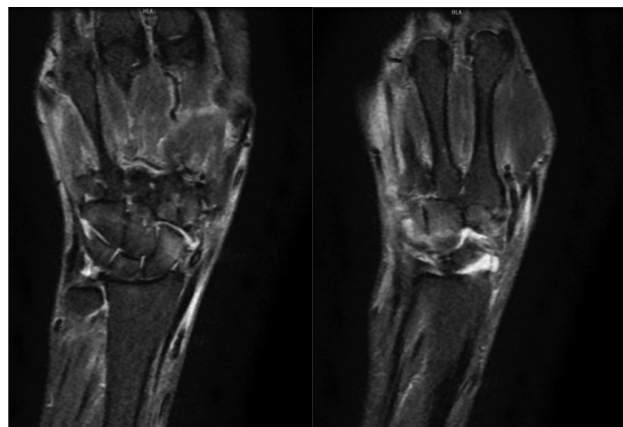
MRI of wrist joint. In MRI investigation, synovial effusion in both wrist joint and tenosynovitis of extensor tendons were detected
